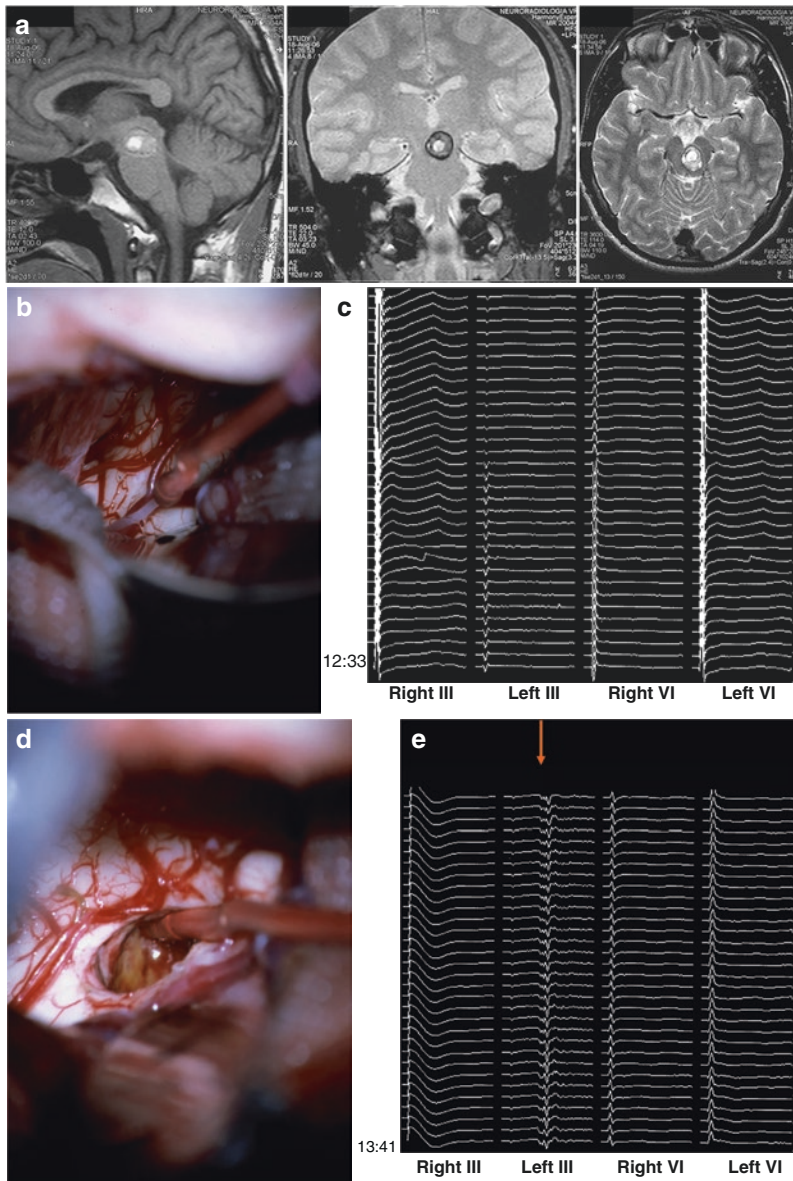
Identification of the oculomotor nerve nuclei at the level of the tectal plate. (a) Sagittal (left), coronal (middle), and axial (right) magnetic resonance images of a left paramedian midbrain cavernoma. (b) Upon exposure of the superior colliculi, initial (time 12:33) direct stimulation of the left colliculus does not elicit any response from the oculomotor muscles innervated by the III and VI cranial nerves (c). (d) Later on (time 13:41), stimulation from inside the surgical cavity, during removal of the cavernoma, elicits a consistent response (red arrow) from the left upper rectus muscles (Left III), indicating stimulation of the nearby nuclei (e). Abbreviations: Right III, right upper rectus muscle; Left III, left upper rectus muscle; Right VI, right lateral rectus muscle; Left VI, left lateral rectus muscle. (Modified with permission from Sala et al. [36])
